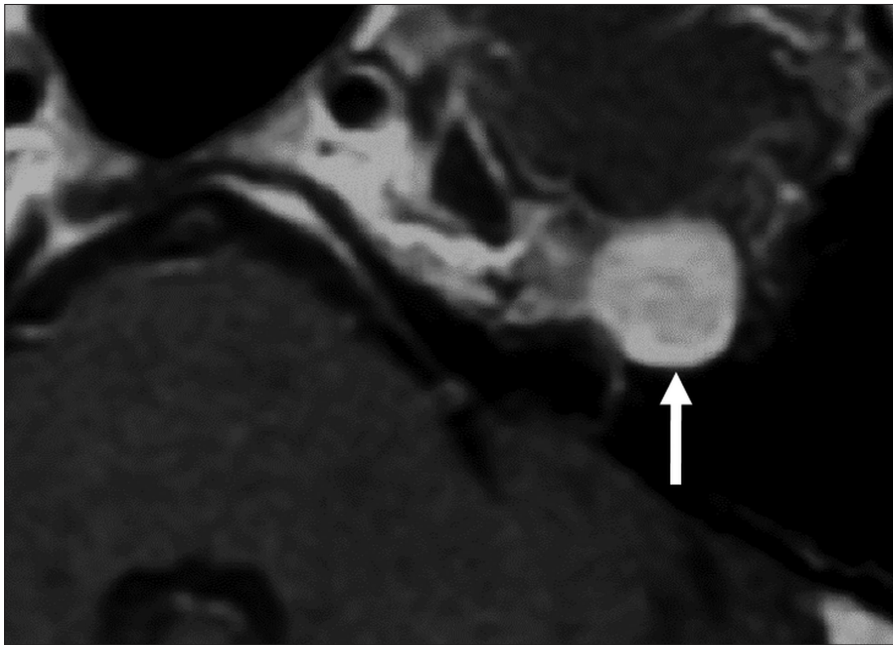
Contrast-enhanced axial T1-weighted image through the pons at the level of left internal auditory canal shows FNS involving the GG with no extension to other segments. This mass shows smooth scalloping of the adjacent bone on CT (not shown), which is compatible with FNS and excludes the possibility of a facial nerve hemangioma.
